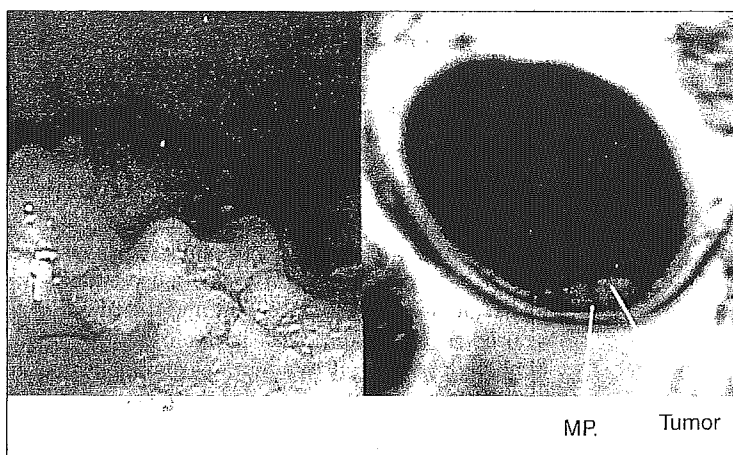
A case of T2 tumor examined by air enema technique. Left: endoscopic image; Right: MR image of the lesion; MP: proper muscle layer.
